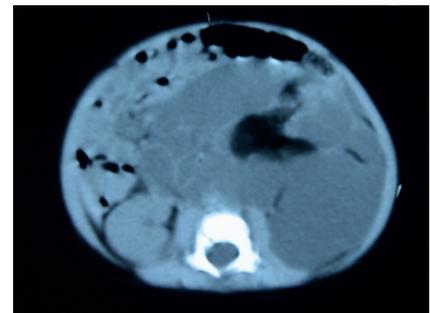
CT scan showed a large, cystic, heterogeneous mass extending across the midline
